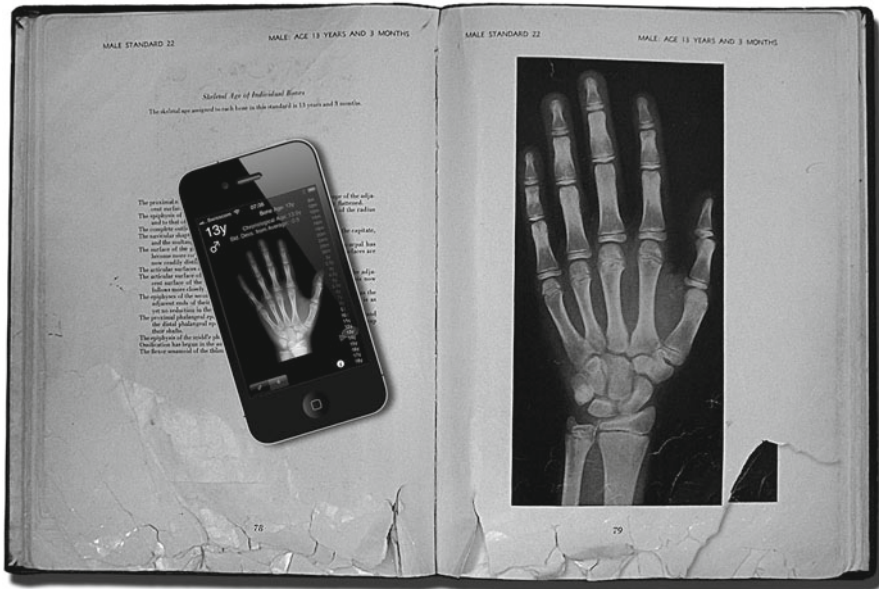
Comparison of the traditional Greulich and Pyle atlas used for determination of bone maturity from hand radiographs and the electronic alternative, a digital atlas of “idealized” hand radiographs that can be reviewed on standard hand-held PDAs
